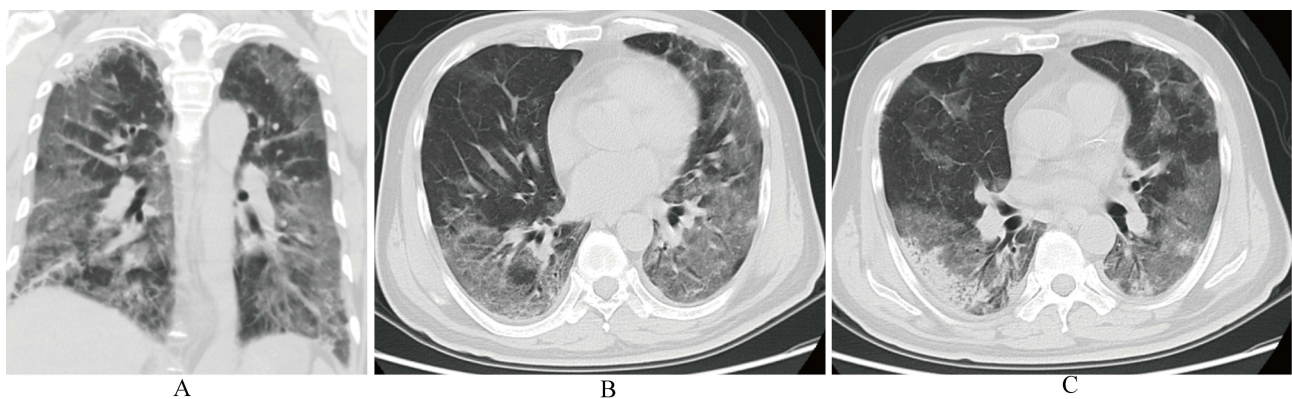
Chest computed tomography (CT) scan. (A) Sagittal chest CT scan shows bilateral thoracic cage is symmetrical, diffuse ground-glass opacities and reticular patterns are observed in both lungs; (B) Coronal view demonstrates bronchovascular bundle thickening in both lungs, with diffusely distributed ground-glass opacities and reticular patterns. Bilateral pleural thickening is also observed; (C) Multiple ground-glass opacities are observed in the subpleural regions and along the bronchovascular bundles in both lungs, accompanied by localized interlobular septal thickening, most pronounced in the subpleural areas, patchy consolidations and air bronchograms are also visible.
